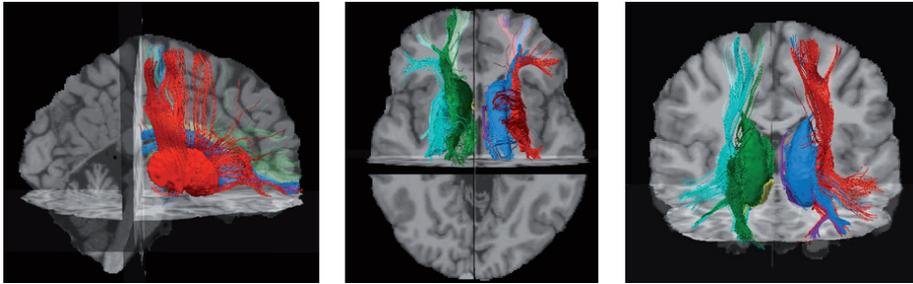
Sagittal, axial, and coronal views of striatal structures and corticostriatal tracts for one subject, superimposed on the T1-weighted scan. Yellow and purple = nucleus accumbens and accumbens tract; green and blue = caudate nucleus and caudate tract; turquoise and red = putamen and putamen tract.
